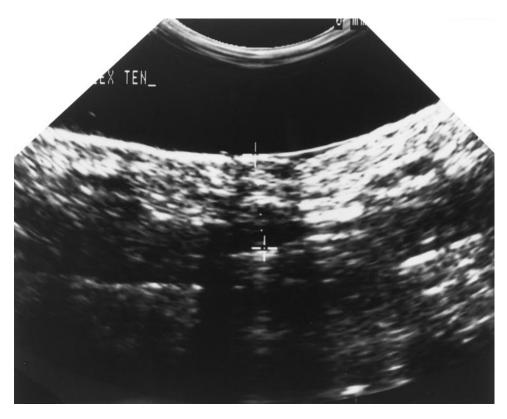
Ultrasound of the MCP joint. The actual structures are not well delineated. The flexor tendons are located deep to the lower cross hairs. Tendon motion is easily seen in real time. The cord is located between the cross hairs. (Reprinted with permission.<sup>19</sup>)
